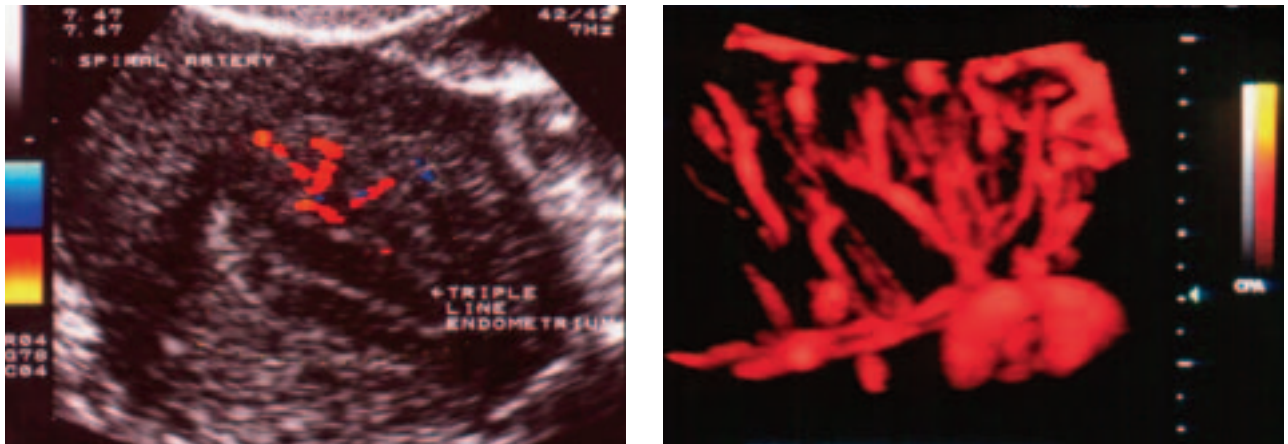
2D and 3D power Doppler image showing spiral arteries supplying triple-line endometrium, important for future implantation.
